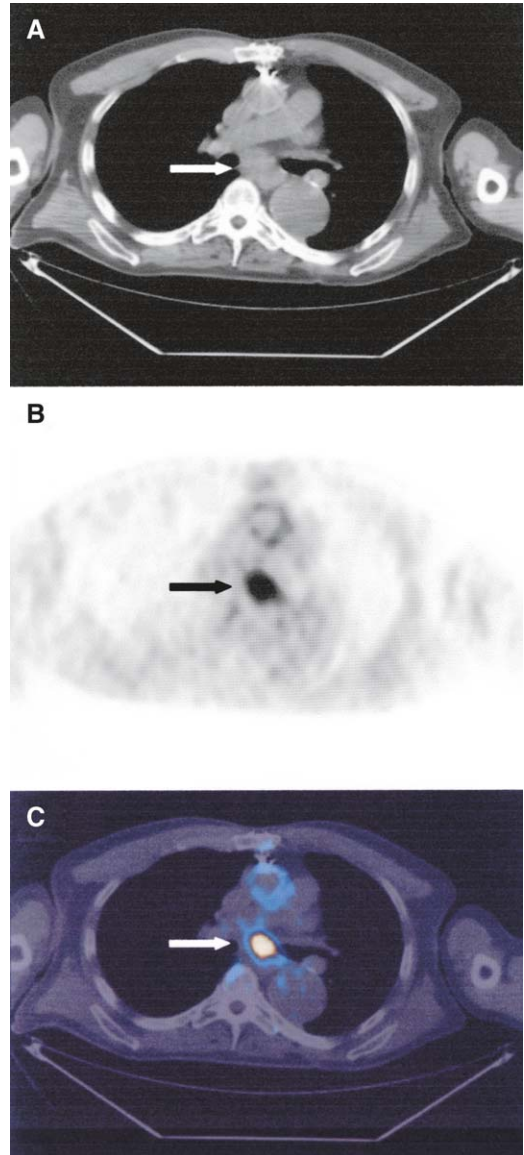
CT/PET fusion study depicting malignant periesophageal lymph node. The arrow indicates the malignant node in each panel. (A) Noncontrast CT image. (B) FDG-PET image. (C) CT/PET fusion image.
